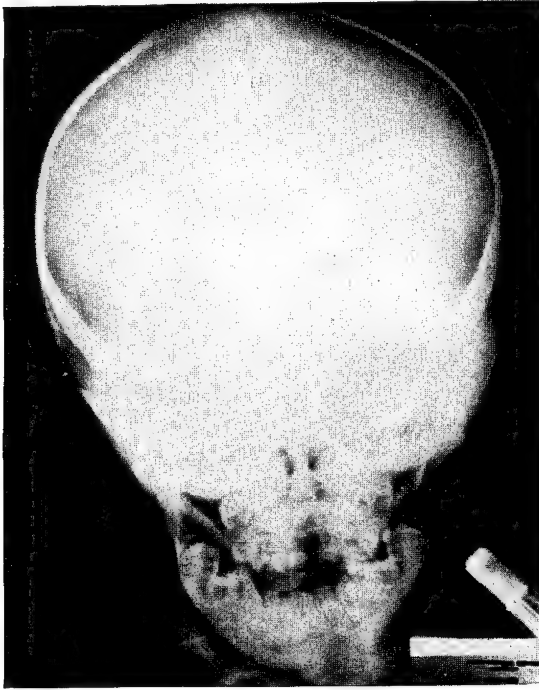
Roentgenogram of skull.
